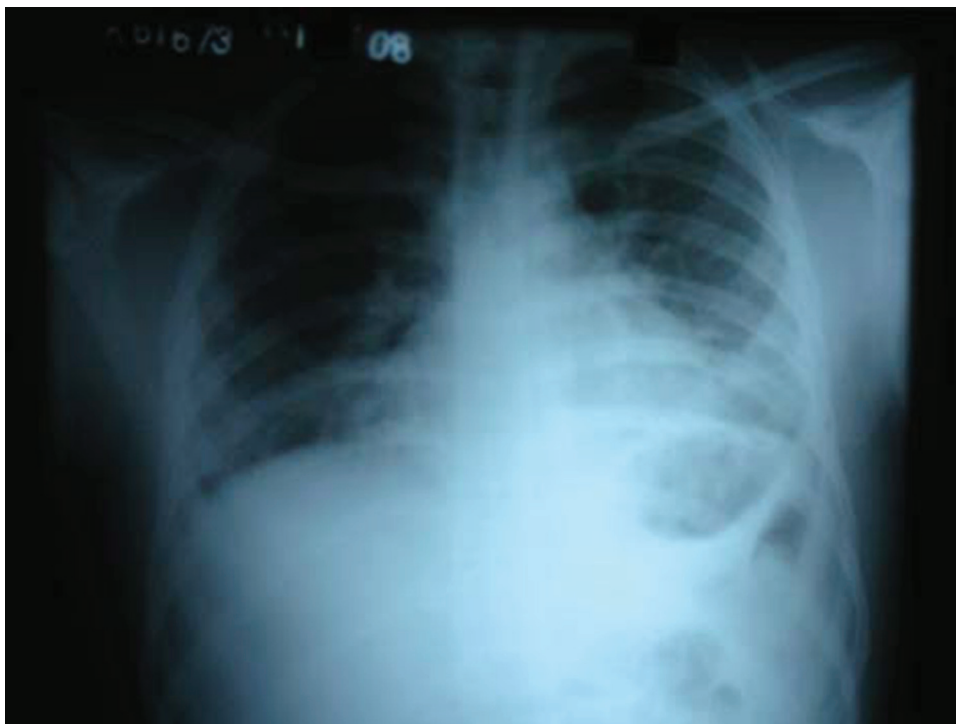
Chest x-ray plate posteroanterior view showing bilateral lower zone consolidation.
